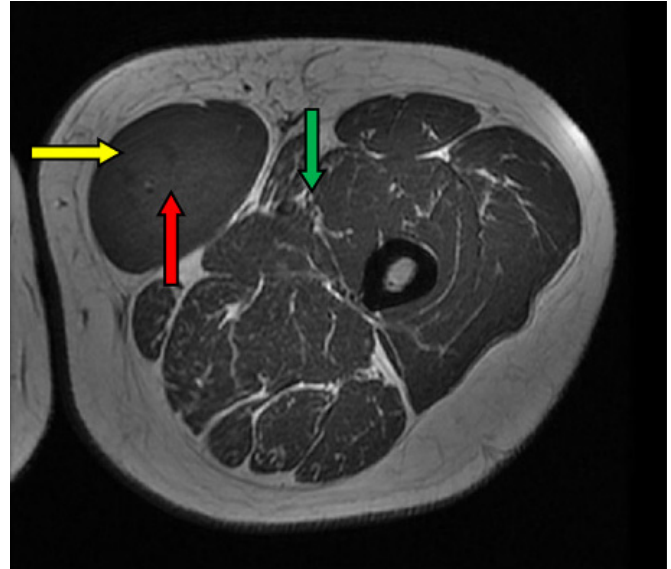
B. Axial MRI view of the tumor. Yellow arrow marks tumor margin, green arrow marks neurovascular bundle approximately 1.5-2 cm from the tumor margin, red arrow marks the great saphenous vein encased in tumor.
